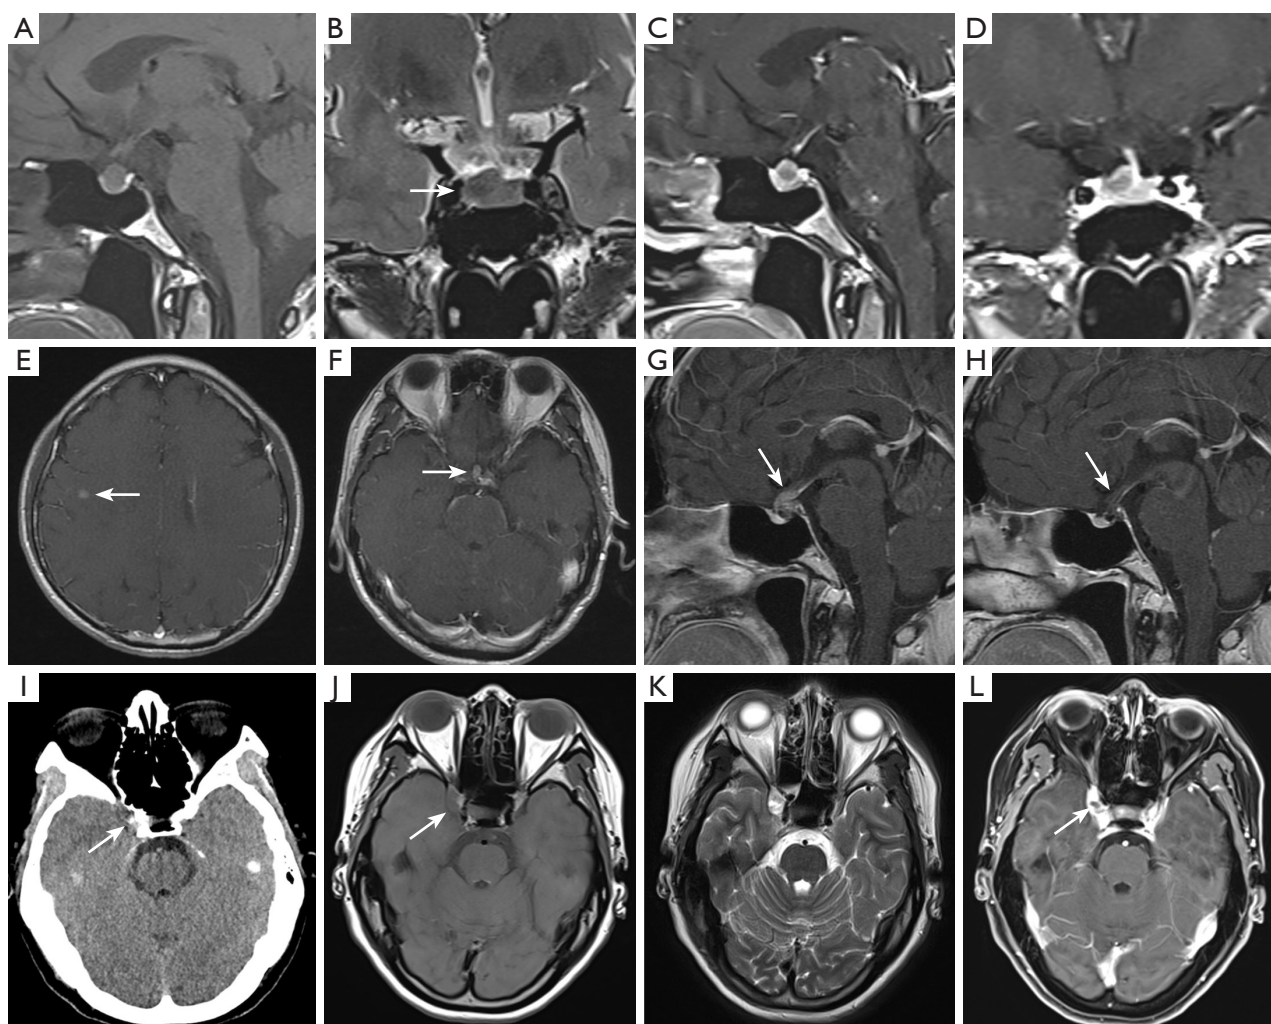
Blind spot in brain imaging: sella and parasellar region. (A-D) Scans of a 41-year-old female patient, who had undergone surgery for a small intestinal neuroendocrine tumor and chemotherapy for liver metastasis, and who underwent pituitary region examination to rule out multiple endocrine neoplasia. MRI revealed a nodule as slightly hypointense on T_1 WI and T_2 WI (arrow), while a contrast-enhanced scan showed that the nodule was less enhanced than that of the surrounding normal pituitary tissue. The pituitary stalk was shifted to the left (D), suggesting a diagnosis of a pituitary microadenoma. (E-H) Scans of a 56-year-old male patient with left upper lobe lung cancer and multiple metastases. The brain MRI revealed brain metastasis (arrow) (E); however, the thickening of the pituitary stalk in the scanned area of brain MRI was missed (arrow) (F). Due to the patient's symptoms of polydipsia and polyuria, the pituitary MRI was performed, which revealed thickening of the pituitary stalk (arrow) (G). After therapy, the lesion appeared less distinct than it had previously (arrow) (H). Follow-up confirmed the diagnosis of metastasis. (I-L) A 42-year-old female patient with a history of headache for 3 years, accompanied by right eyelid ptosis and periorbital pain. CT showed an easily missed, low-density nodule in the right parasellar region (arrow) (I). MRI revealed a scalloped nodule in the right cavernous sinus (J-L), which appeared slightly hypointense on T_1 WI (arrow) (J) and mixed isointense to hyperintense on T_2 WI/FS (K). Enhanced scans showed the nodule with obvious heterogeneous enhancement (arrow) (L). Postoperative pathology confirmed the diagnosis of the meningioma. MRI, magnetic resonance imaging; T_1 WI, T1-weighted image; T_2 WI, T2-weighted image; CT, computed tomography; FS, fat saturation.
